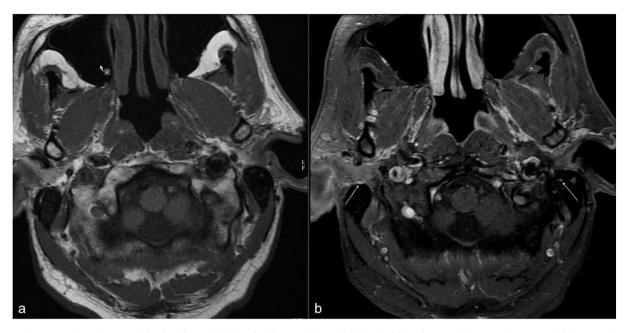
Magnetic resonance imaging, T1 weighted axial cuts with (a) and without gadolinium (b) showing bilateral VII cranial nerve enhancement (white arrows), at the level of the mastoid segments.
